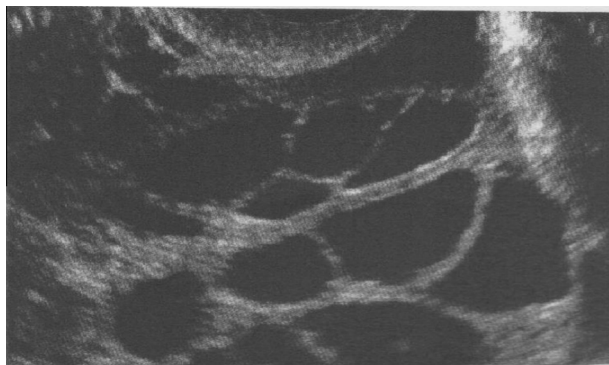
Ultrasound Image of multiloculated ovarian cyst.
